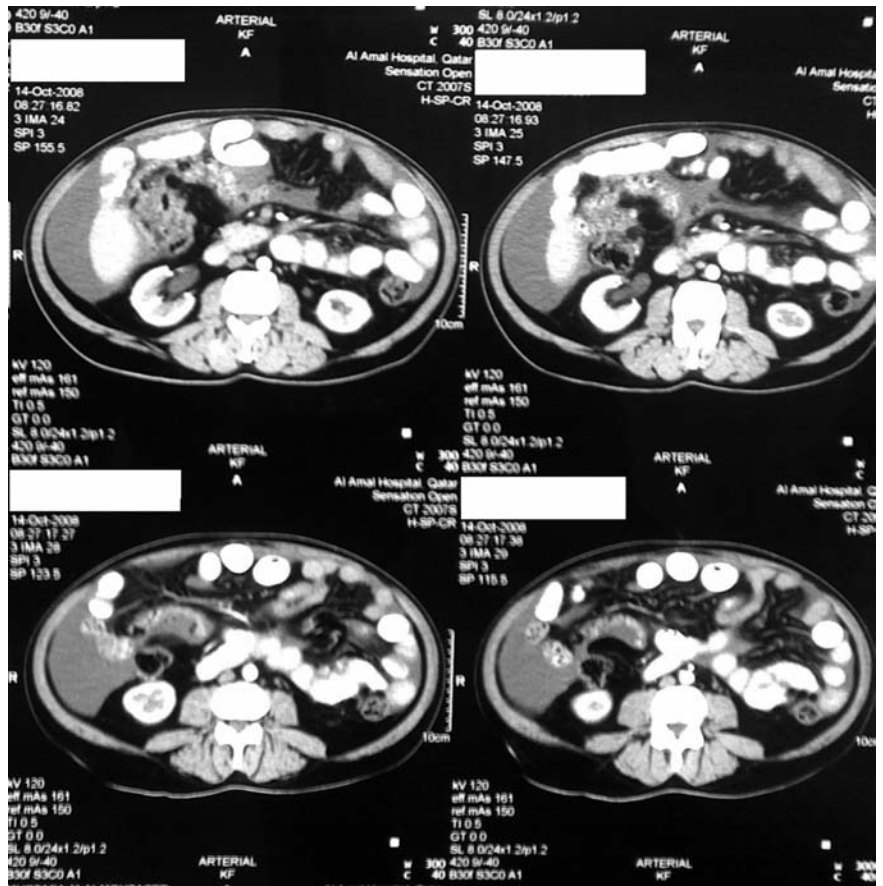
CT scan in October 2008 showed peritoneal thickening and ascites.
